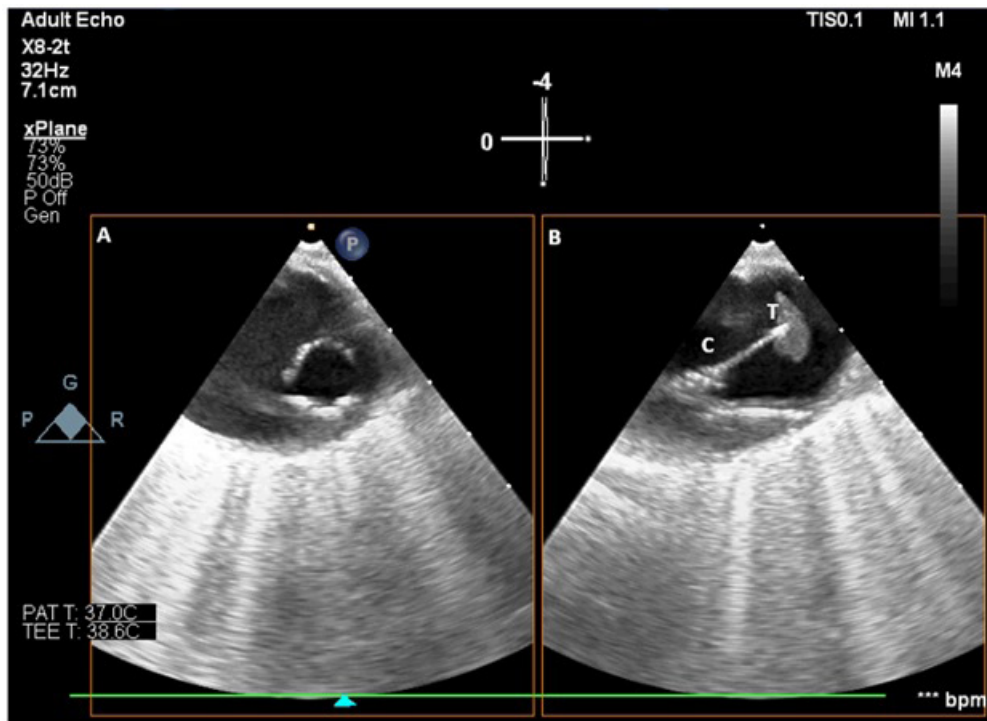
TEE image of the descending aorta showing capture and evacuation of intra-aortic thrombus using flared cannula advanced under transesophageal ultrasound guidance. (A) Descending thoracic aorta short axis view, (B) Descending thoracic aorta long axis view, (C) AngioVac flared cannula, (T) aortic thrombus.
